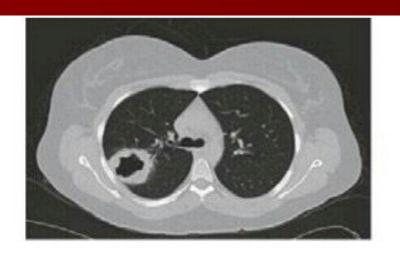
2 Computed tomography of the chest in two patients with granulomatosis with polyangiitis (Wegener's) demonstrating (A) single and (B) multiple cavitary lung lesions.
